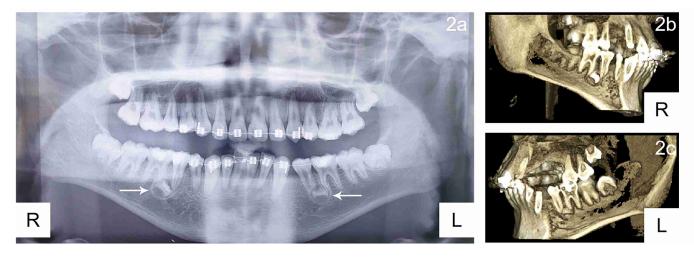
Preoperative radiographic examination. Preoperative panoramic radiography (2a) and cone-beam computed tomography (2b, 2c).
